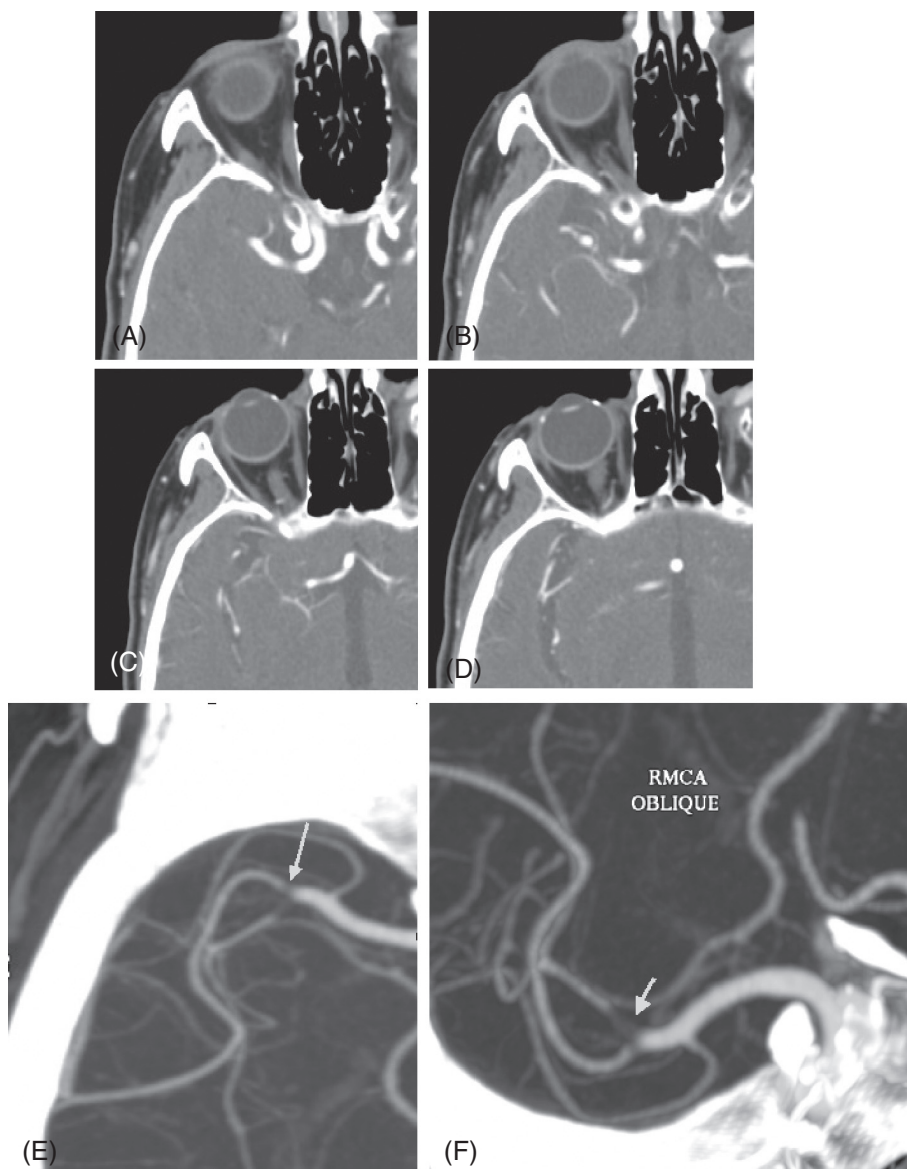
Importance of maximum-intensity projection images for detection of small segmental occlusions. Occlusive thrombus at right middle cerebral artery bifurcation is very difficult to detect on sequential axial source CTA images (A–D) though very conspicuous on maximum-intensity projections (E, F arrows). Good opacification of vessels distal to occlusion by collateral flow is noted.
